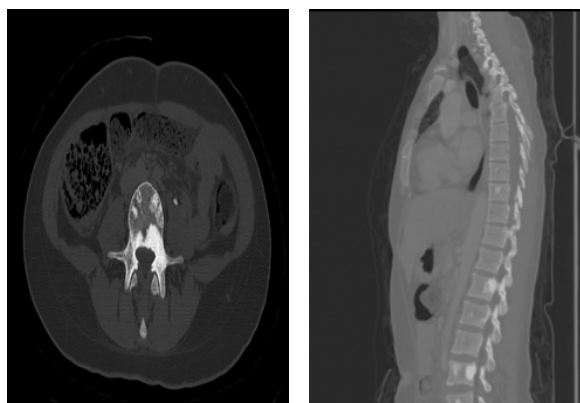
CT scan images in bone window, axial and sagittal cuts, showing diffuse and layered osteocondensing lesions in the thoracolumbar vertebrae without cortical rupture.
